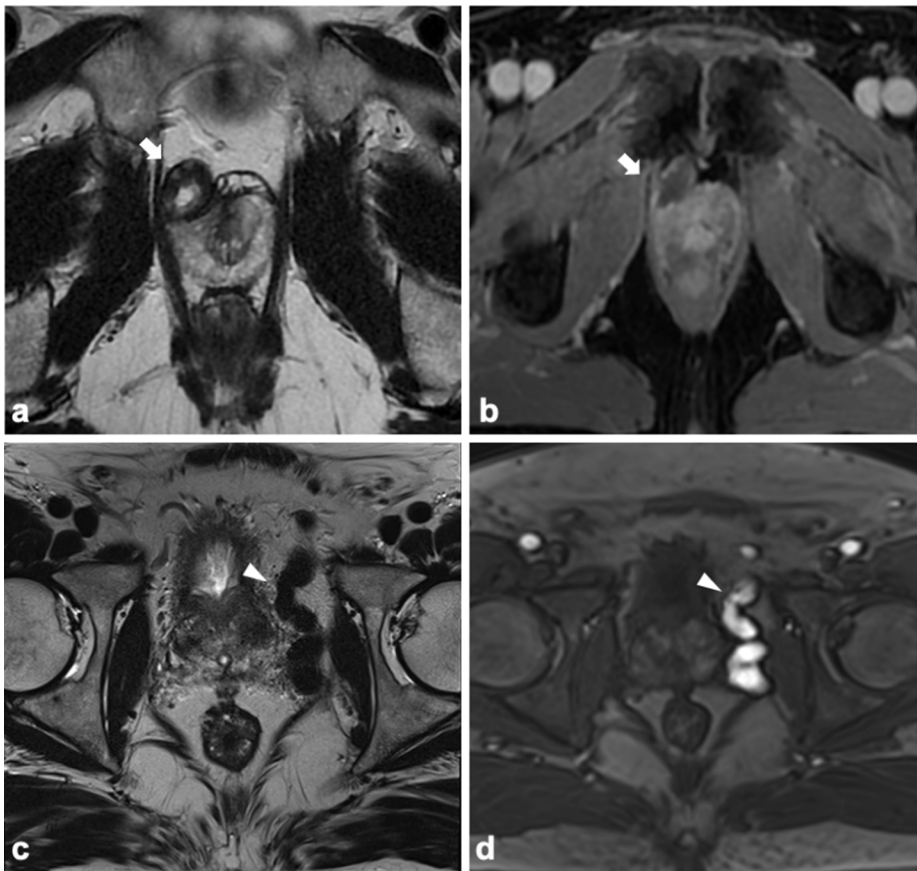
Axial T2w (a) and post-contrast fat-sat T1w (b) images show a well circumscribed heterogeneous T2-signal mass with peripheral enhancement (arrows) in the right periprostatic space, confirmed at biopsy as schwannoma. Axial T2w image shows hypointense tubular structures in the left peri-prostatic space (arrowhead in c), corresponding to ectatic vessels, characterized by precocious arterial enhancement on axial DCE image (arrowhead in d), in keeping with arteriovenous malformation. T2w T2-weighted, T1w T1-weighted, DCE Dynamic contrast enhanced.
